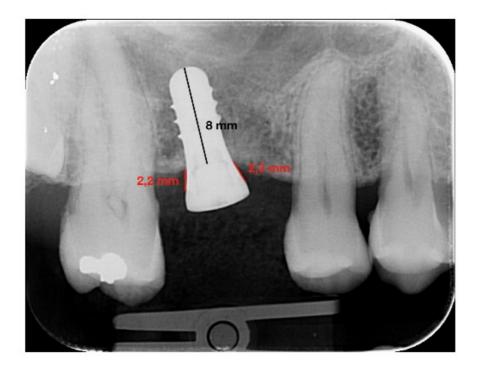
Example of x-ray measurement for MBL: it was measured calculating the distance between the implant neck and the first bone-to-implant contact. In the example, 8 mm was the length of the implant used for calibration, while 2.3 and 2.2 mm indicate the mesial and distal MBL measurement respectively.
